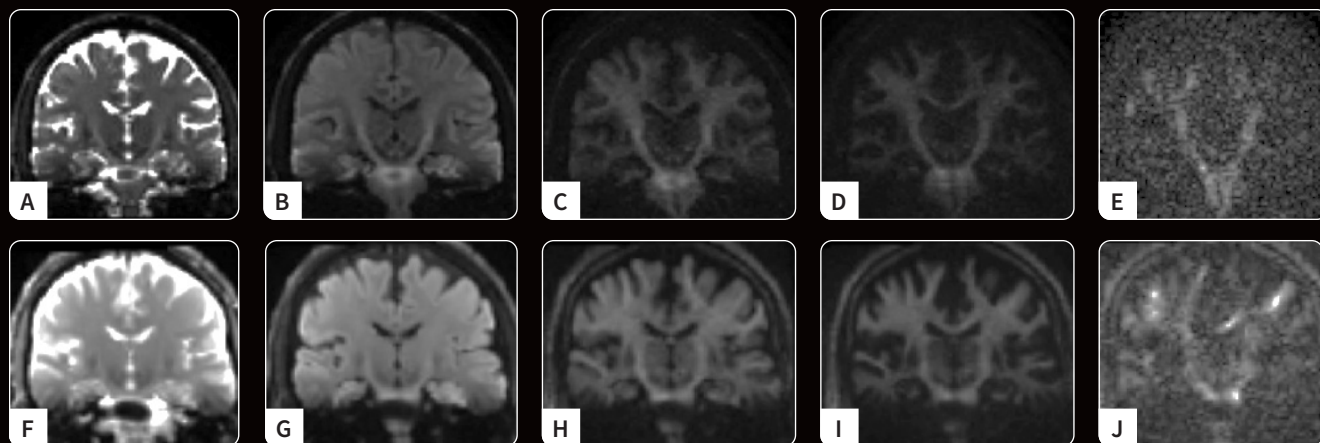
Comparison of directionally averaged 1.5 mm isotropic DWI on (A-E) Discovery™ MR750, TE=110 ms, versus (F-J) MAGNUS, TE=49 ms, at b-values up to 10000s/mm². (A, F) b=0, (B, G) b=1200, (C, H) b=4800, (D, I) b=10000 and (E, J) a single DWI image at b=10000 s/mm². The SNR is increased by roughly 2.4x on the MAGNUS system.
